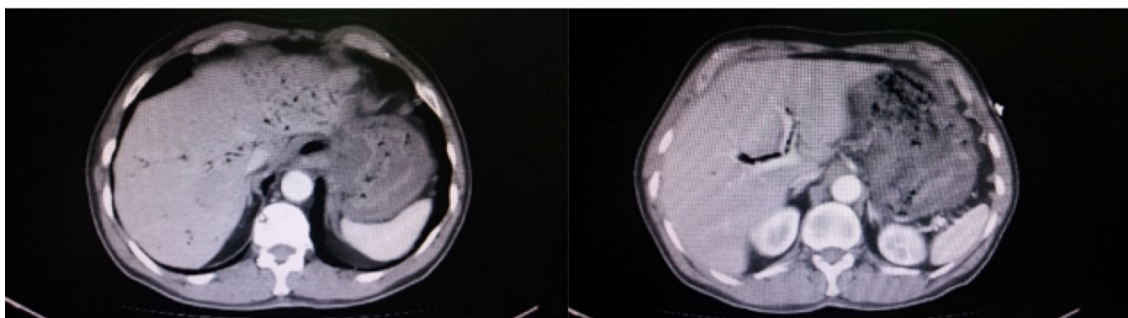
CT image indicating pneumobilia and esophageal wall thickening at day 1 after MEKP accidental oral intake
